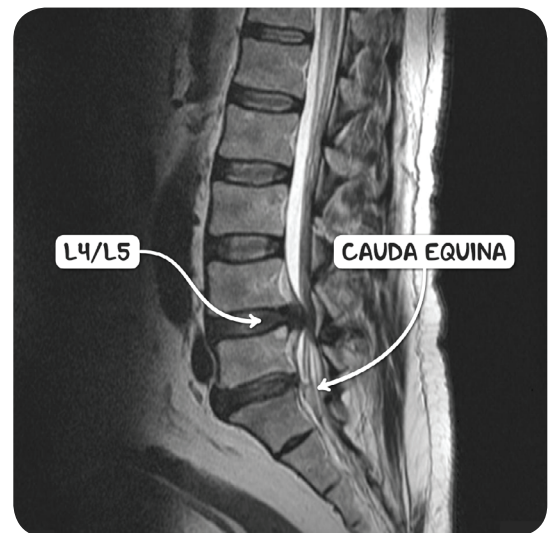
An MRI scan of the spine in the sagittal plane demonstrating a L4/L5 intervertebral disc prolapse compressing the cauda equina. The individual presented with symptoms of cauda equina syndrome.
